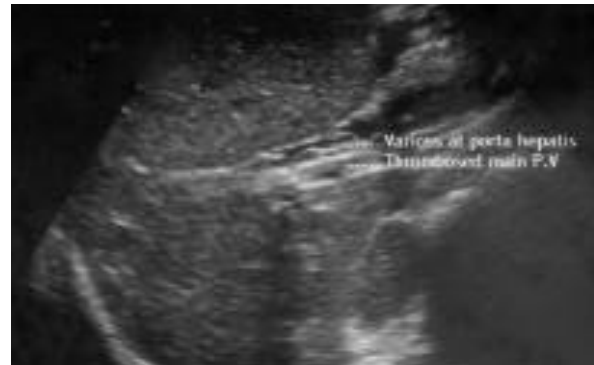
Abdominal ultrasound at the level of portal vein (PV) showing thrombosis within the main portal vein with varicoses at porta hepatic.
